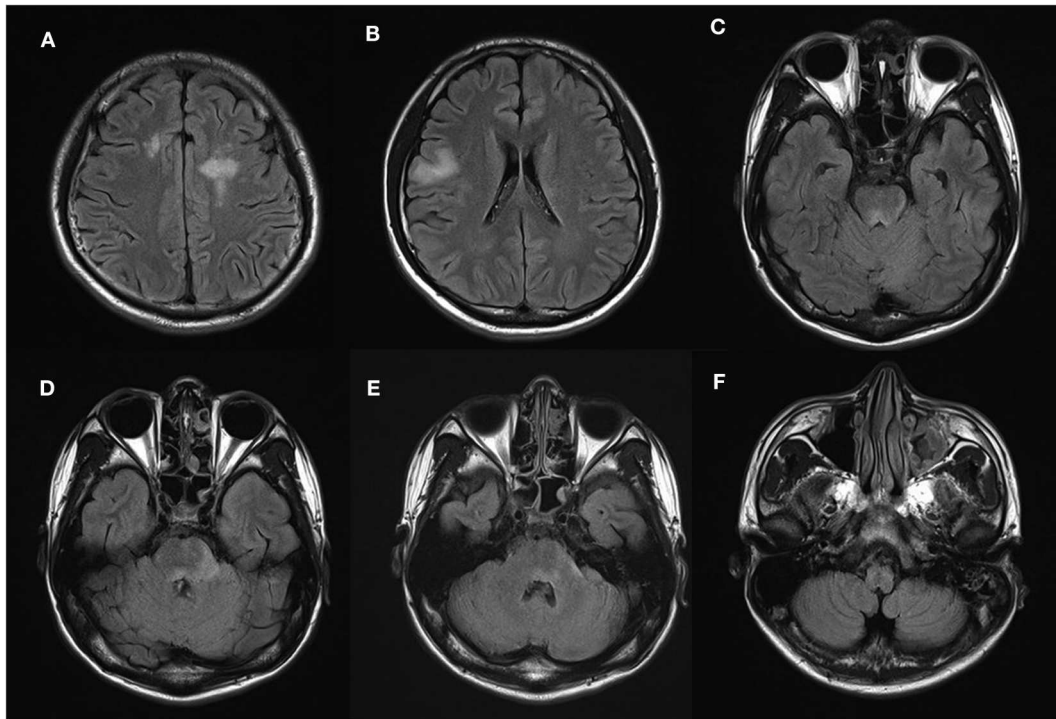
Participant 1 shows high fluid-attenuated inversion recovery (FLAIR) signal abnormalities in (A,B) bilateral cerebral hemispheres, (C) poorly demarcated dorsal midbrain, and (D,E) pontine lesions around the fourth ventricle. (F) No area postrema lesion is observed.
